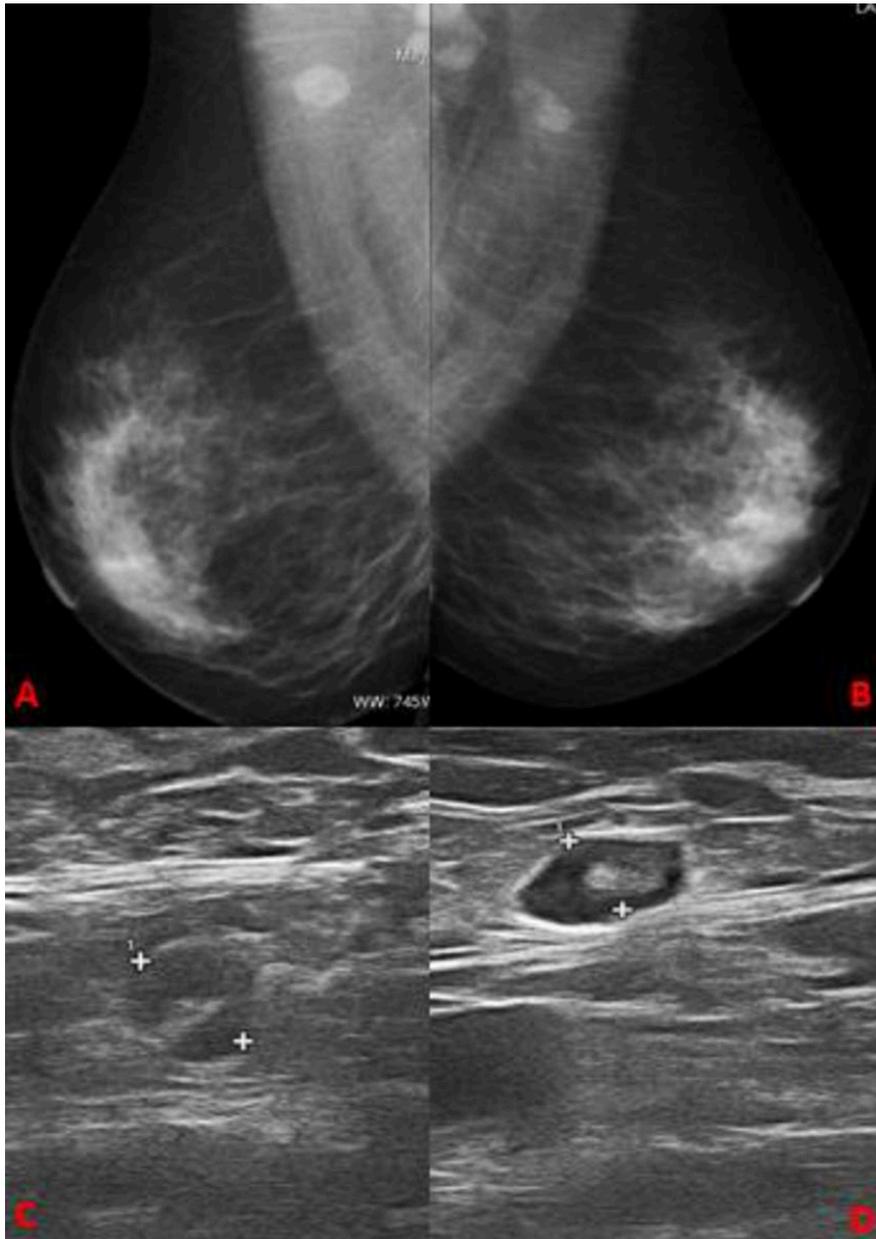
Bilateral MLO (mediolateral oblique) (A/B) mammograms in this 56-year-old woman with a palpable node in the right axilla, show no pathologic findings in the breast but bilateral dense adenopathies are seen. The US (ultrasound) of both axillas demonstrated adenopathies with the normal hilar fat. The FNAB (fine needle aspiration biopsy) showed findings consistent of sinus histiocytosis.
